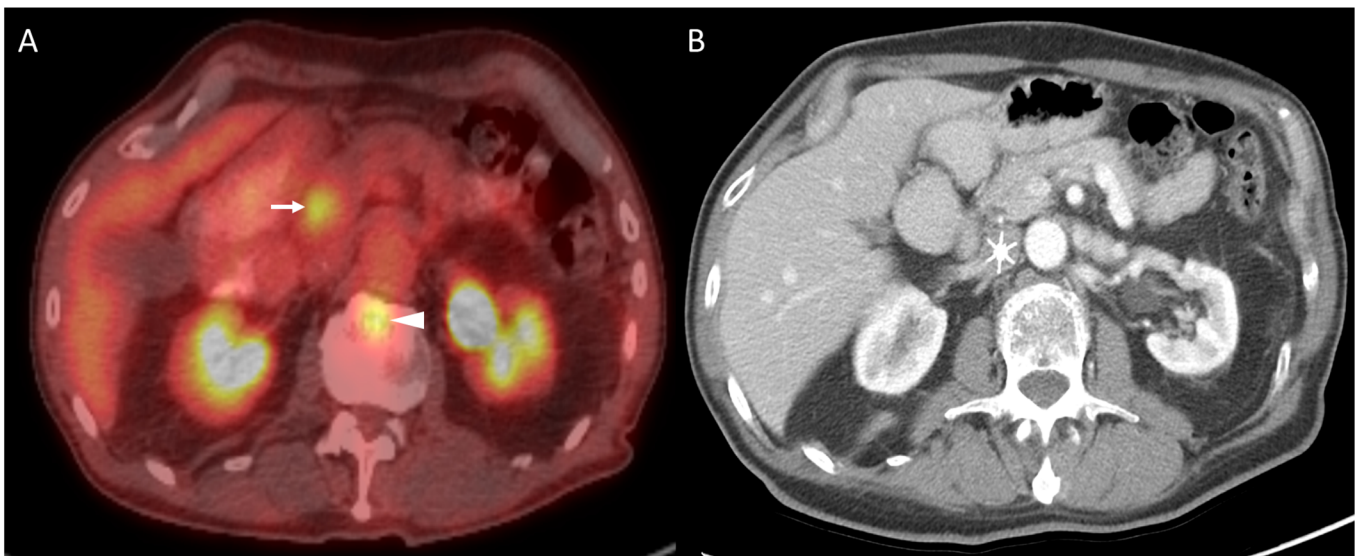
A 47-year-old male with a UrC-ADC. Axial fused PET/CT (A) demonstrates an FDG-avid pancreatic lesion (arrow), SUV_{max} 14.2, and additional osseous metastasis lesion (arrow head) not detected on prior CECT of the abdomen and pelvis (B). The pancreatic lesion was subsequently sampled by endoscopic ultrasound using fine needle aspiration and proven to be a metastasis.
